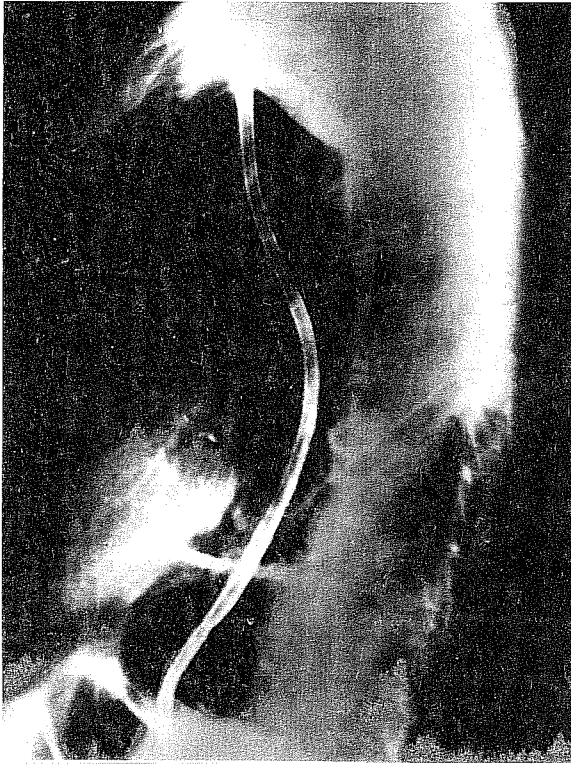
Radiograph showing the balloon obstructs esophagogastric junction and extravasation of radiopaque material into the mediastinum and the left pleural space.
